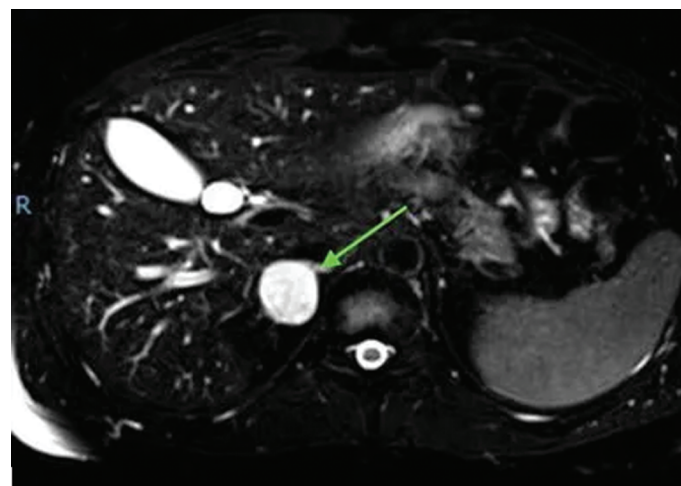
T2-weighted MRI with fat suppression shows pheochromocytoma of right adrenal gland (arrow) that exhibits high signal “light bulb sign.”³³
